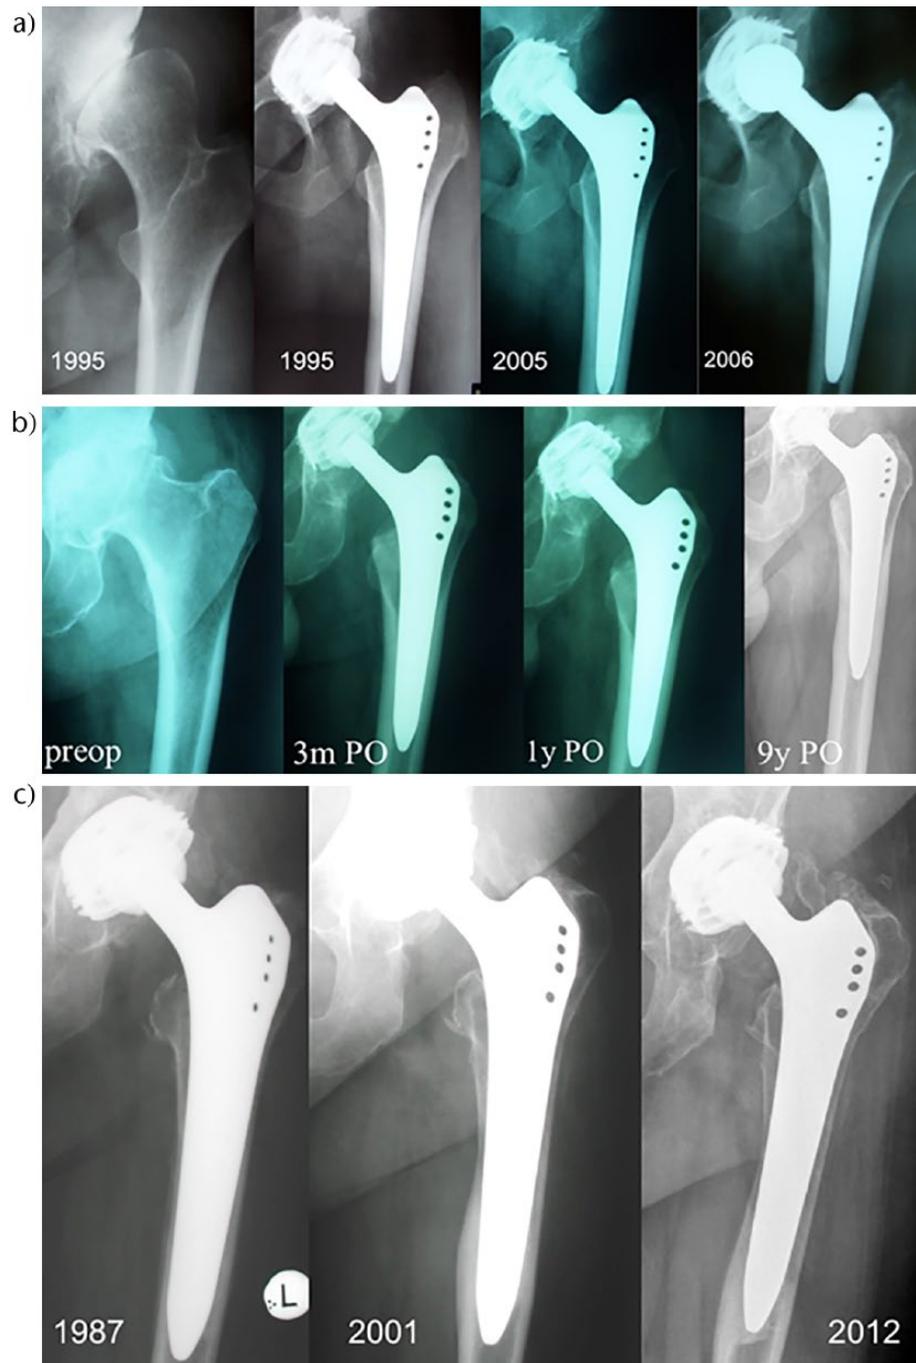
a) Successive AP radiographs of an Alloclassic SL® stem immediately following surgery, and ten years and eleven years post-operatively, showing proximal cortical atrophy mainly in Gruen zones 1, 2, 6 and 7, indicating stress-shielding. b) Sequential AP radiographs of an Alloclassic SL® stem at three months, one year and nine years post-operatively showing cortical diaphyseal hypertrophy developing combined with proximal stress-shielding. c) Sequential AP radiographs of an Alloclassic SL® stem showing the adaptive behaviour of the stem in patients with osteoporosis.
